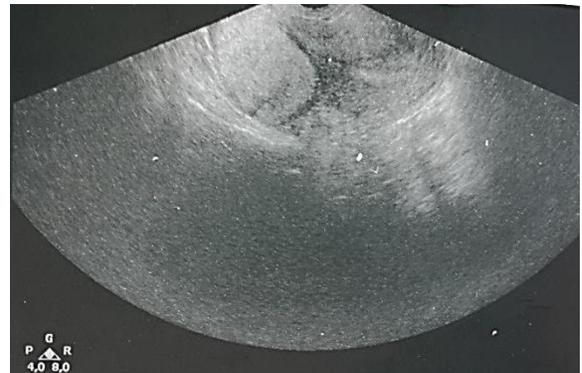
Sagittal sonogram shows hyperechoic mass arising from the cervico-isthmian region.
